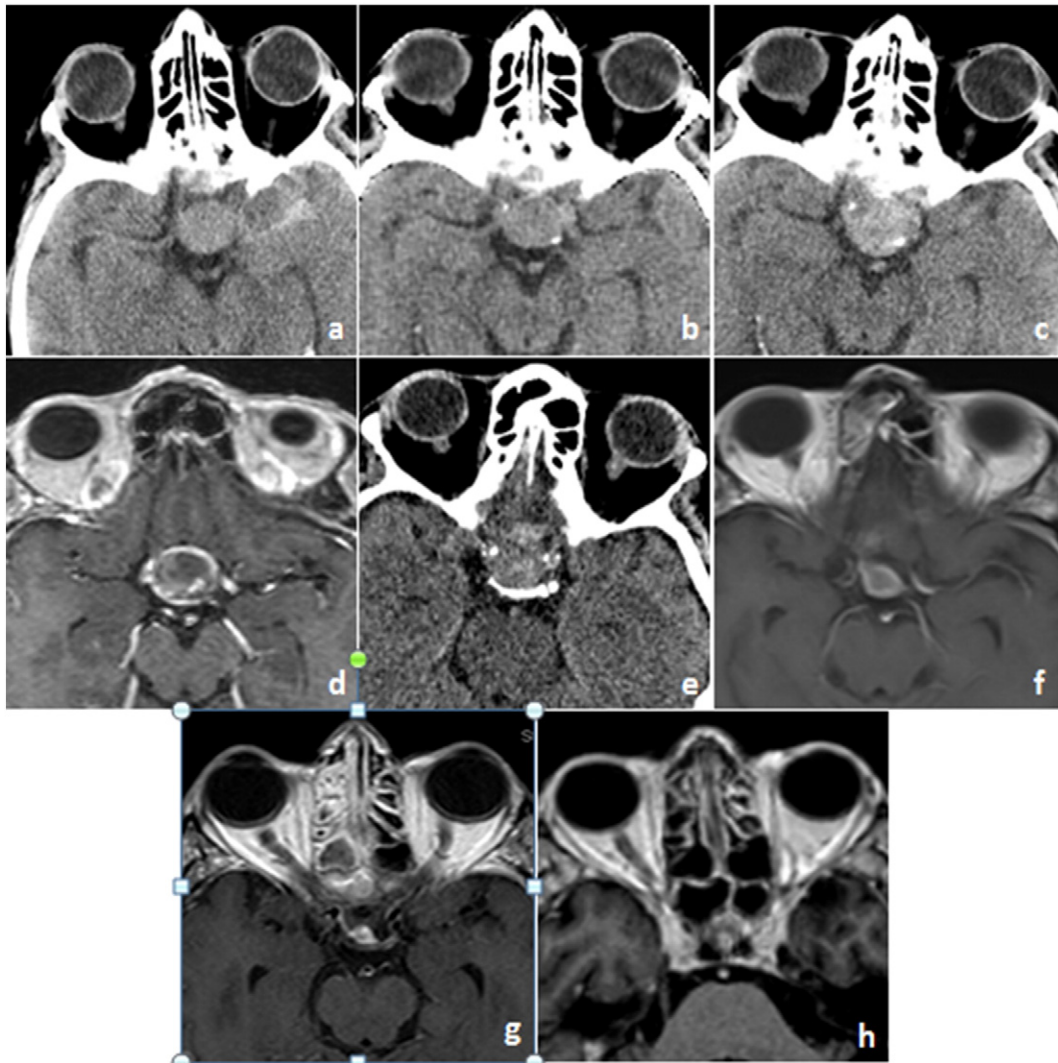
Early after head trauma axial brain CT scan (a) and 6 h later brain CT scans (b); 24 h axial brain TC scan; recognition of pituitary apoplexy and first manifestation of symptoms (c); 36 h later T1 contrast enhanced axial brain MRI scan: aggravation of neurological condition (d) and 48 h later post-apoplexy CT axial scans (e). Postoperative axial T1 contrast enhanced brain MRI axial scans (f). Early (g) and long term follow up T1 contrast enhanced brain MR axial scan (h).
